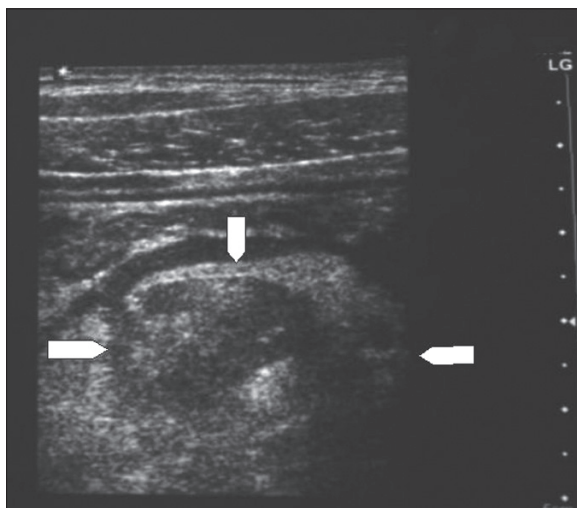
Case 2. Ultrasound of the right iliac fossa: heterogeneous appendicular mass.
